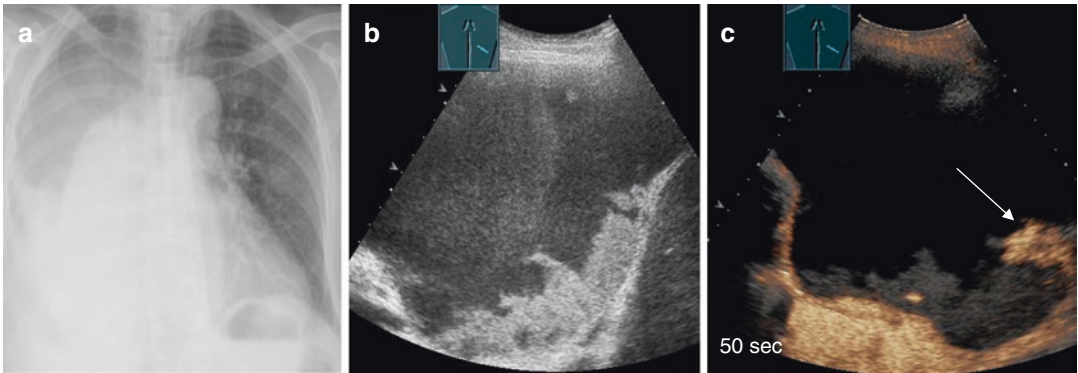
Patient with dyspnea, pulmonary effusion, and confirmed pulmonary embolism by CT scan (a); B-mode imaging presents pleural effusion with a homogeneous consolidation of the lung (b); CEUS shows wedge-shaped areas of no enhancement in the consolidated lung suggesting *pulmonary infarction due to central pulmonary embolism* (c)
